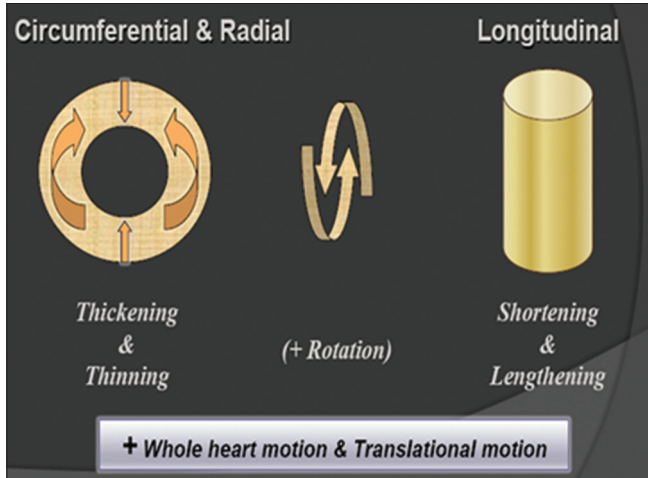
Understanding of the normal pattern of myocardial movement is necessary for comprehensive assessment of tissue Doppler imaging data
